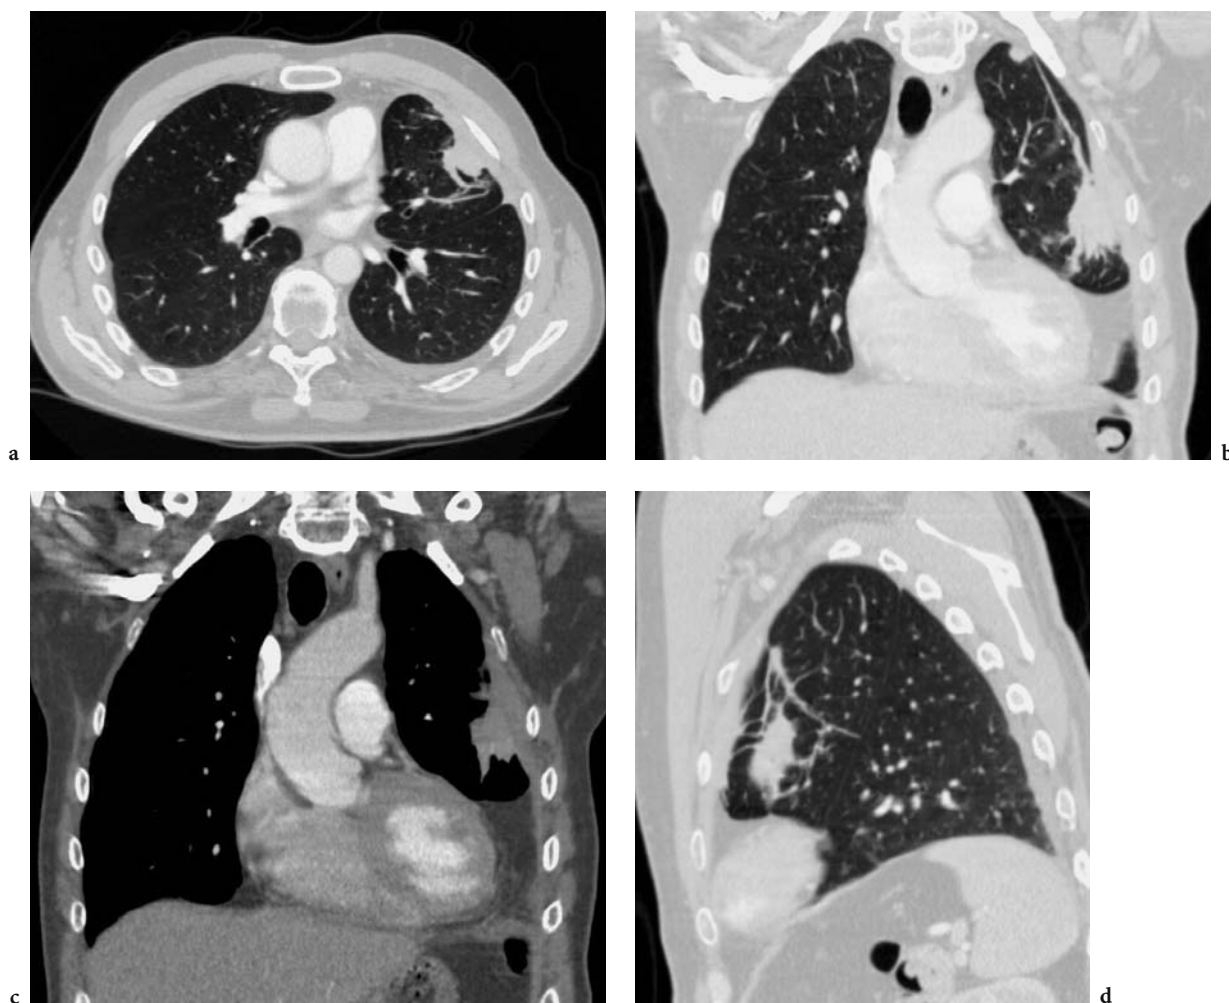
Rounded atelectasis of the lung. b, c Coronal and d sagittal reformations add information to a the axial slice by showing additional curvilinear opacities extending towards the pleural based mass. The CT protocol: acquisition 16×0.75 mm; pitch 0.950; slice thickness, coronal and sagittal reformations 3 mm
